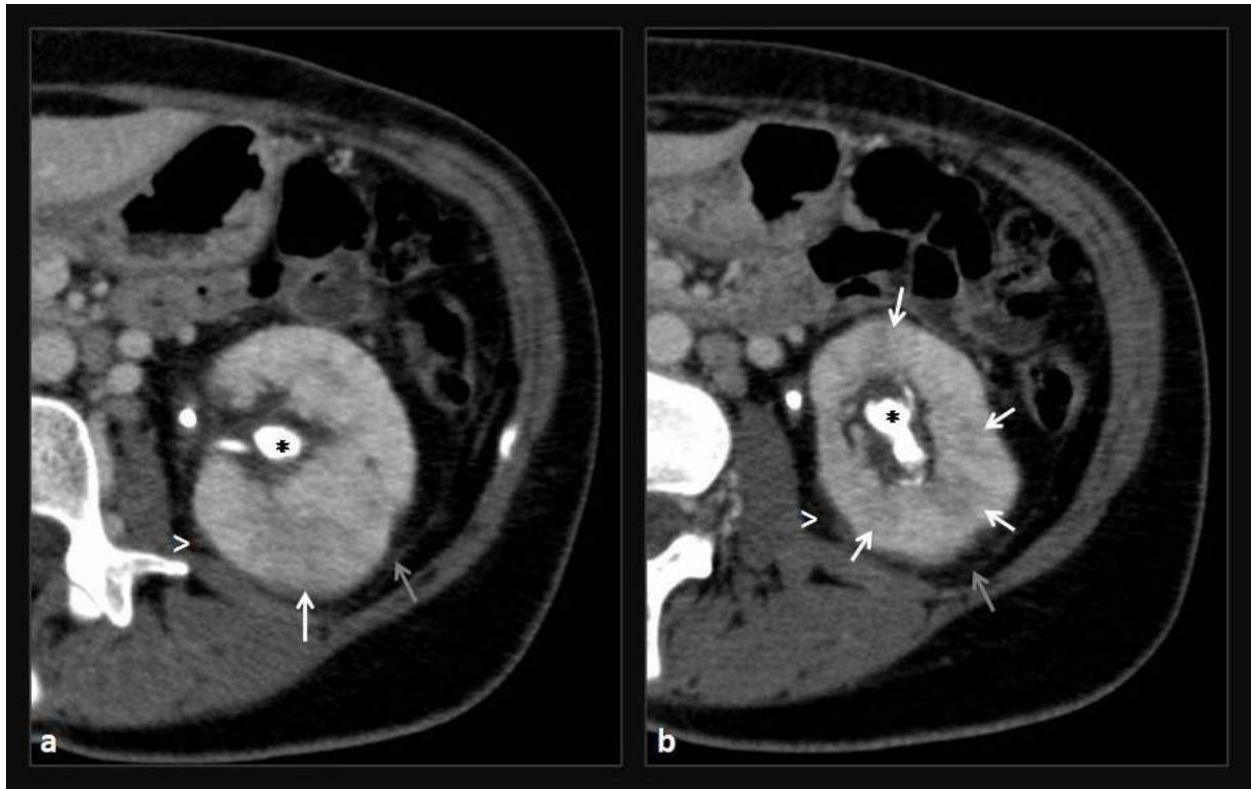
Acute pyelonephritis. Contrast-enhanced axial CT images show several wedged-shape areas of decreased enhancement consistent with a striated nephrogram (white arrows). They also demonstrate a large stone in the renal pelvis (*), perinephric stranding (arrowheads) and thickening of Gerota fascia (grey arrow).
